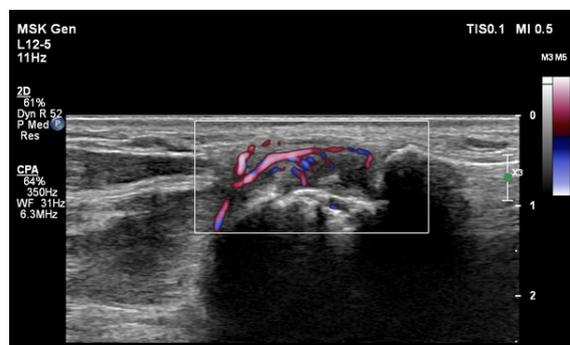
Follow-up ultrasonographic examination after 3 months. Longitudinal dorsal scan of the right second MCP joint demonstrating synovitis with visible active inflammatory erosion.
